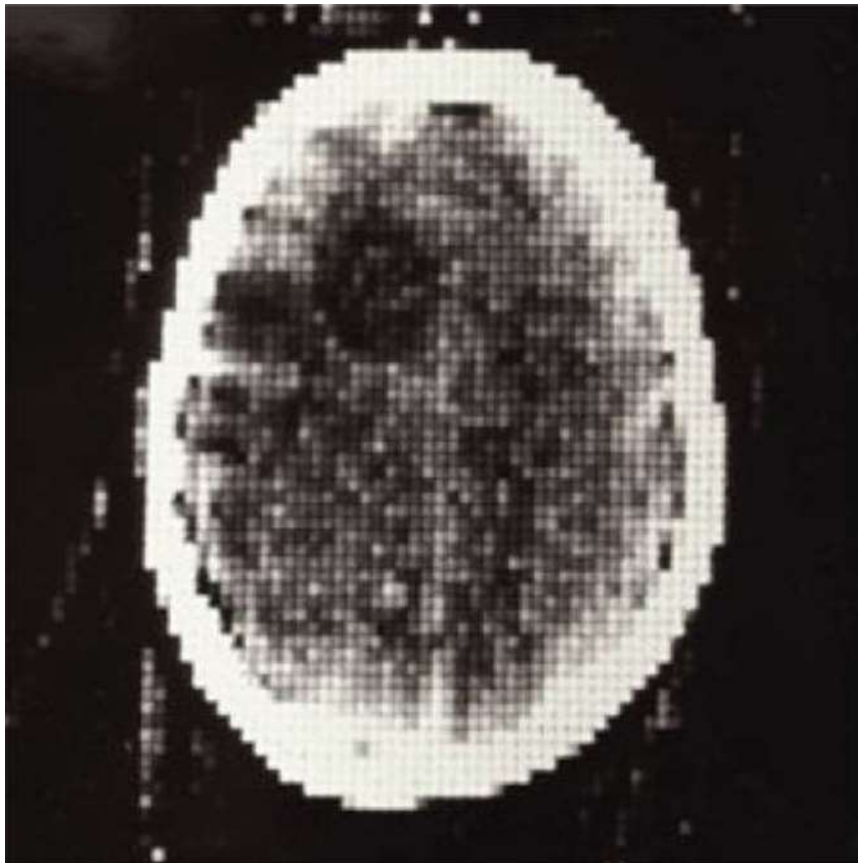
Image acquired by the first clinical CT brain scanner in October 1971 at Atkinson Morley's Hospital in London. A astrocytoma is visualized in anterior right lobe of the brain. Image from Science and Society Picture Library [2]. Copyright for research use only.
